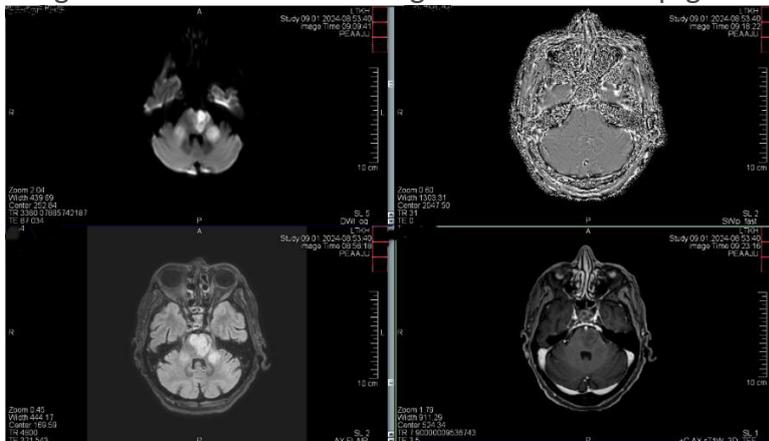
Fifth MRI scan showing ischemic lesions' dynamic in the brainstem and cerebellar peduncles.
